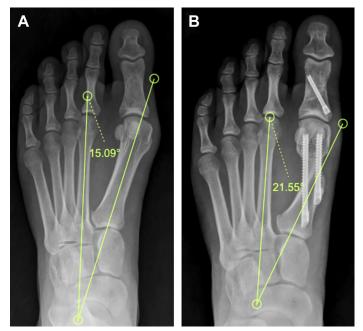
(A) Preoperative and (B) Postoperative radiograph showing an increased varus displacement of the proximal fragment of the first metatarsal osteotomy.
